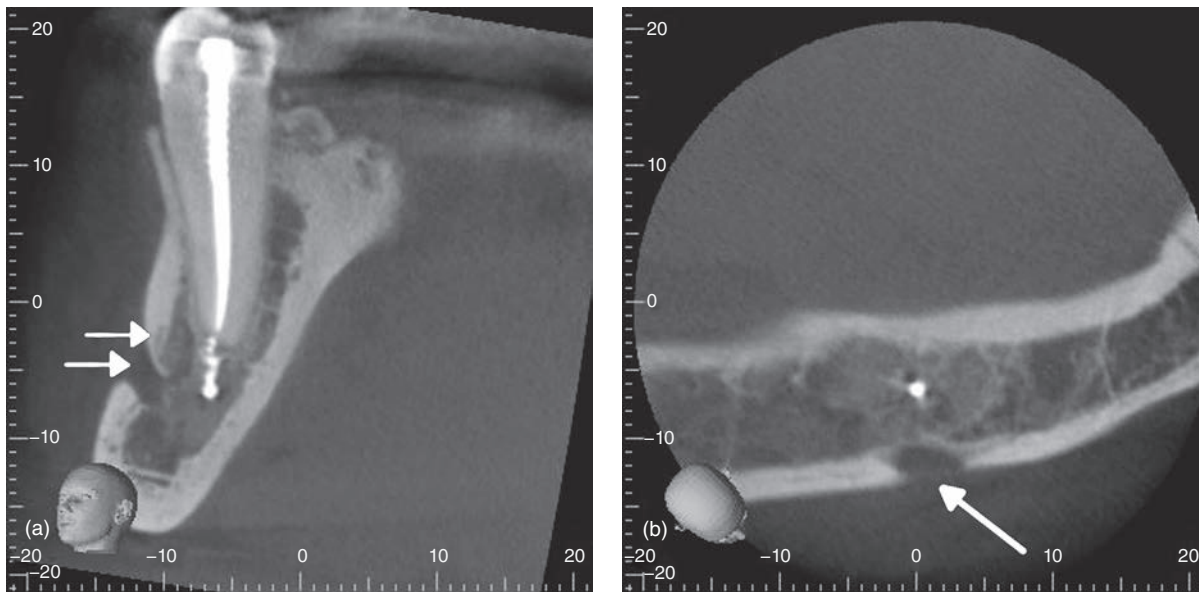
CBCT of #20. (a) Coronal view of #20. Note the closeness of the mental foramen with the apex. (b) Axial view showing the entrance of the mental through the buccal cortical bone.
